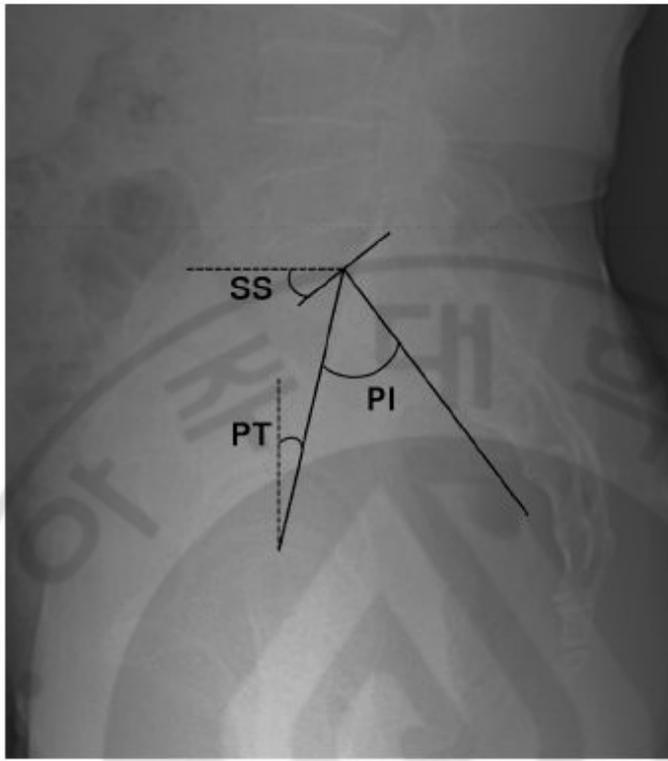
Radiograph showing the measurement of pelvic parameters. pelvic incidence (PI) is defined as the angle subtended by a line connecting the centre of rotation of the hip joint to the midpoint of the endplate of S1 and a perpendicular to the endplate of S1 at its midpoint; sacral slope (SS) is defined as the angle between the superior endplate of S1 and the horizontal plane; pelvic tilt (PT) is defined as the angle between a line joining the midpoint of the superior endplate of S1 and the centre of rotation of the hip with the vertical plane.
